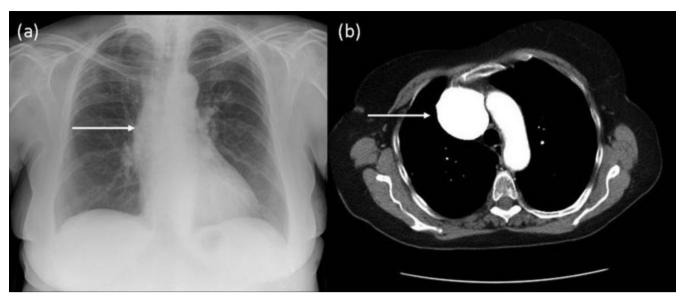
Aneurysmal dilatation of the superior vena cava (a and b) resulting in incidentally detected radiographic abnormality (arrows).
